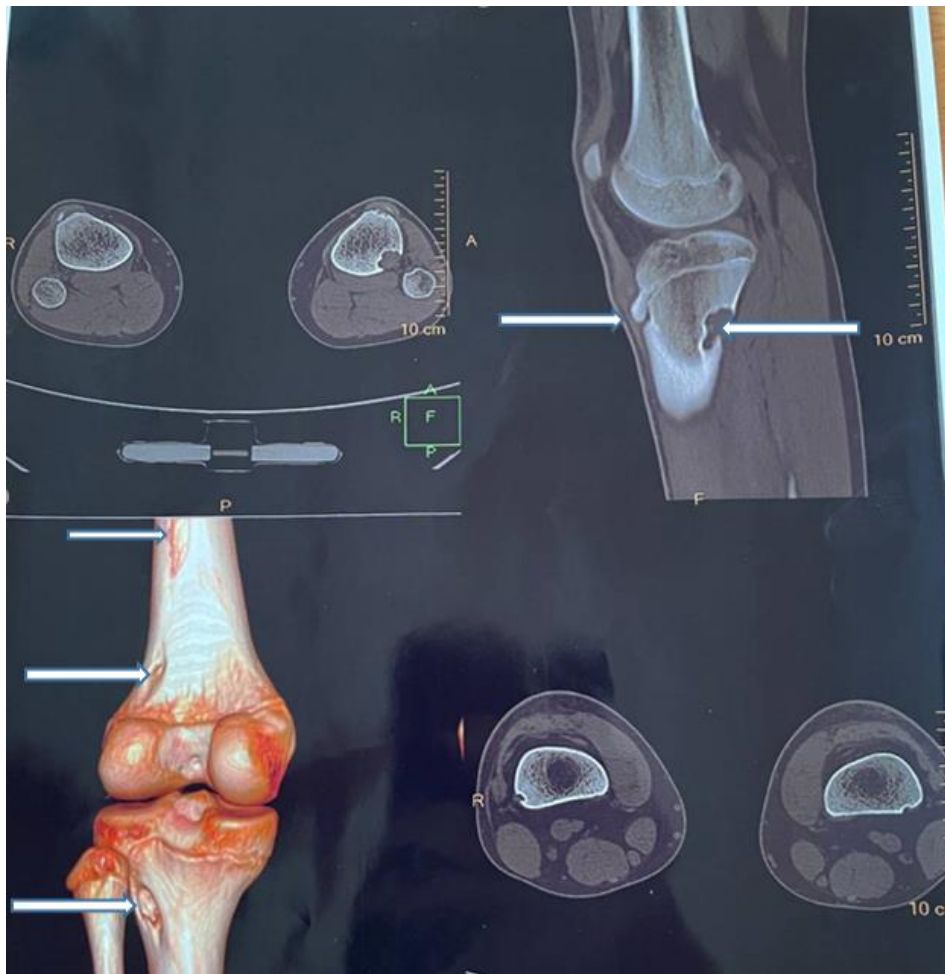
MRI of the right knee. A 17-year-old boy. Massive FCD of the proximal tibia along the outer contour 2 x 1.5 cm. Spindle-shaped FCD of the distal femur portions at different levels 2 x 0.5 cm. Osteochondropathy of the right tibial tubercle (Osgood-Schlatter disease)
